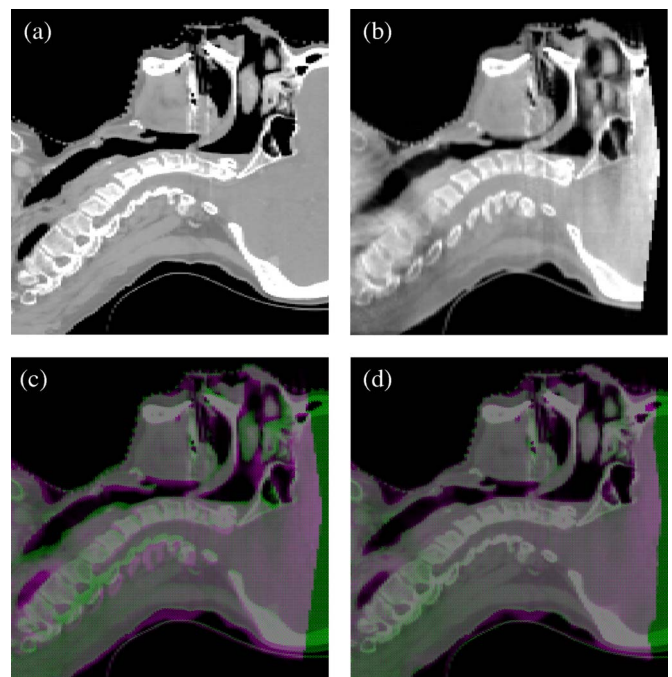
Exemplary CT-CBCT head-and-neck registration: (a) CT as reference and (b) CBCT as target image; (c)/(d) overlays before/after registration.
